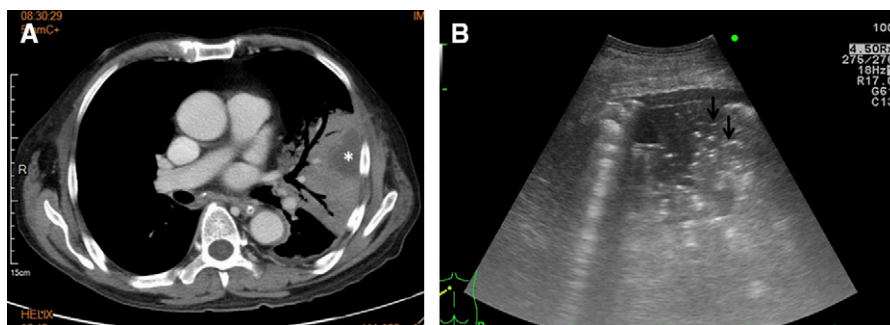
(A) Computed tomography of the chest showing consolidation in the left upper lobe with abscess formation (asterisk). (B) Bedside lung ultrasound showing areas of tissue-like consolidation with linear air bronchograms (arrows).
